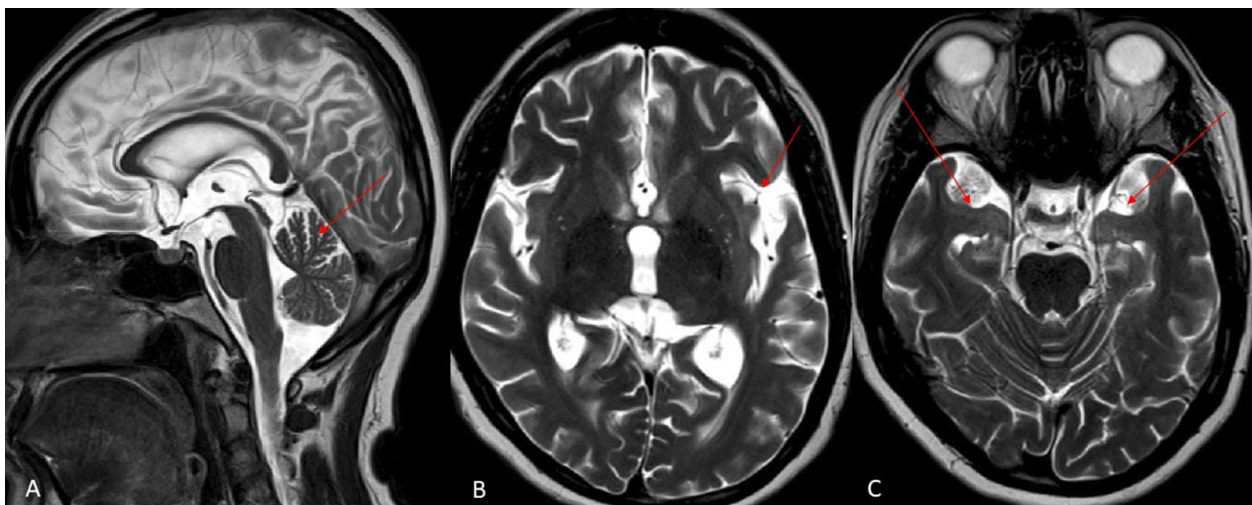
Brain MRI (A) sagittal T2-weighted image shows cerebellar atrophy (red arrow); B axial T2-weighted image shows widening of sylvian fissure (red arrow); C axial T2-weighted image shows bilateral antero-medial temporal lobe atrophy (red arrows)
